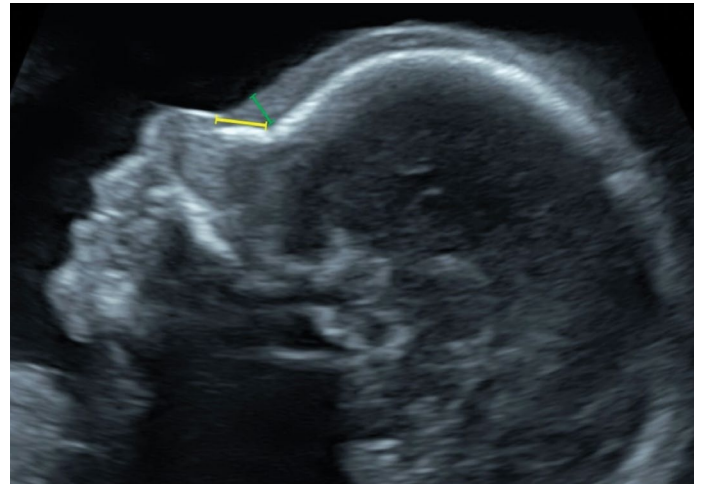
Ultrasonographic image of NBL and PT measurement in the second trimester. Yellow line indicates NBL, green line indicates PT.
